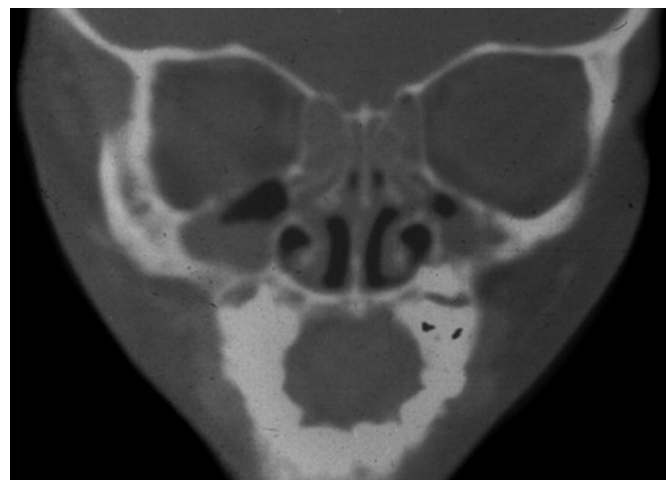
CT scan of patient with classic ostiomeatal complex disease.
